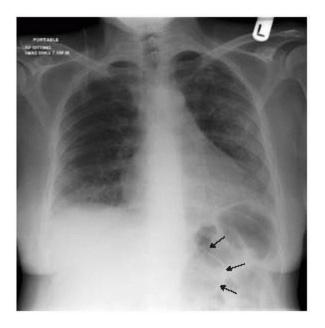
Radiograph showing a correctly placed NG tube.
